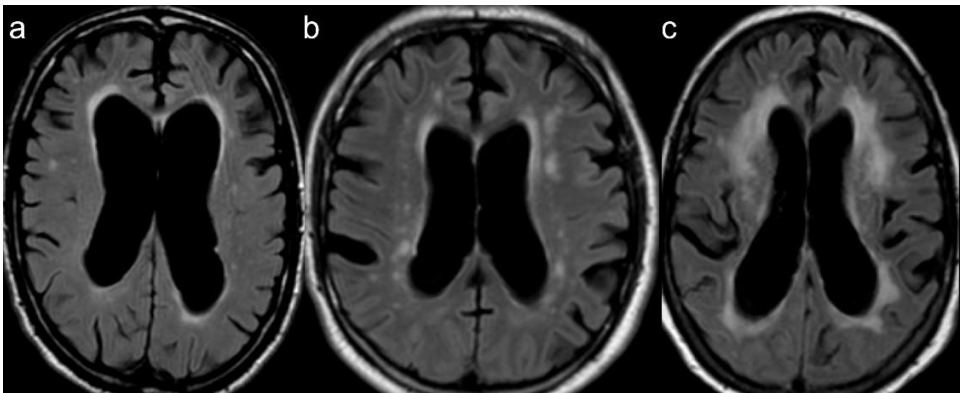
Periventricular and deep white matter hyperintensities graded as 1, 2, 3 according to the Fazekas scale on transaxial, T2-FLAIR images.
